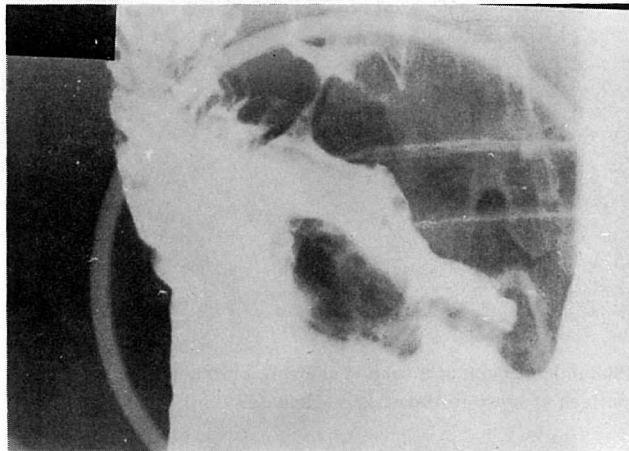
A compression radiograph demonstrating a large polypoid lesion with fairly long stalk.
